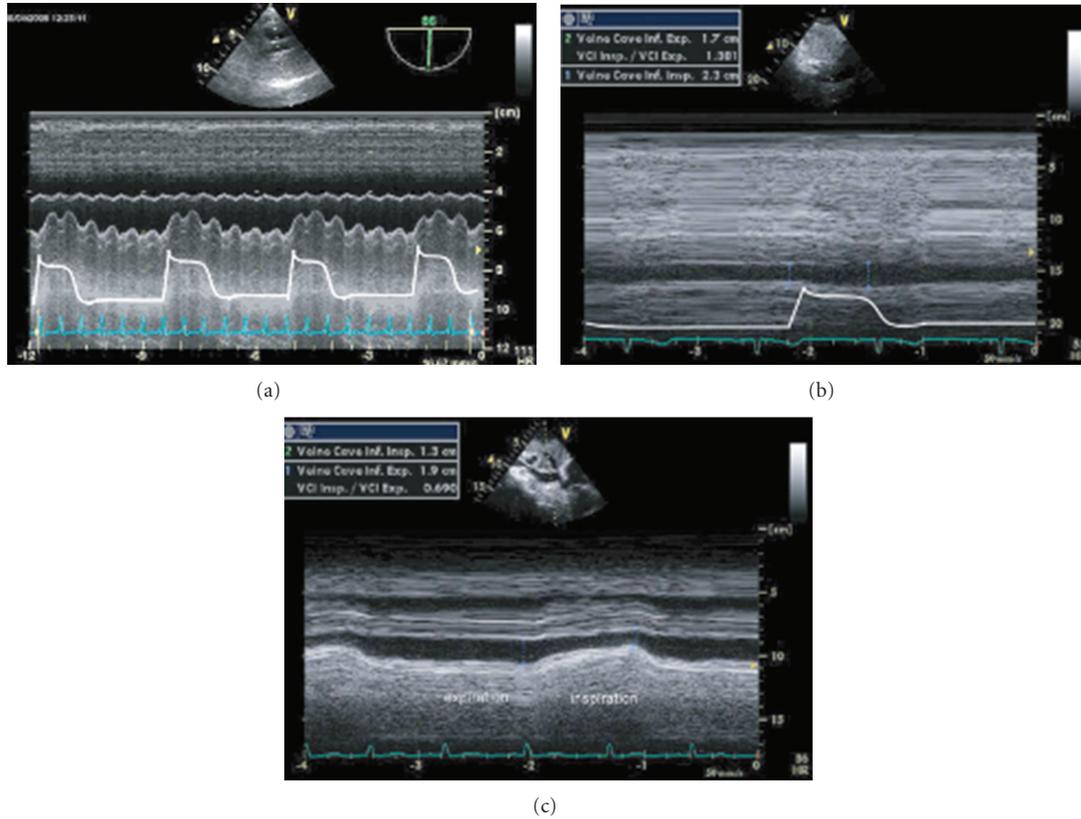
Respiratory vena cava variations in different circumstances. (a) Significant superior vena cava (SVC) collapsibility recorded with transesophageal echocardiography (TEE). (b) Significant inferior vena cava (IVC) distensibility recorded with transthoracic echocardiography (TTE) in a mechanically ventilated patient. (c) Significant vena cava collapsibility recorded with transthoracic echocardiography (TTE) in a spontaneously breathing patient. Reproduced with permission from Levitov et al. “Critical care Ultrasonography” Mc Graw Hill 2009.
